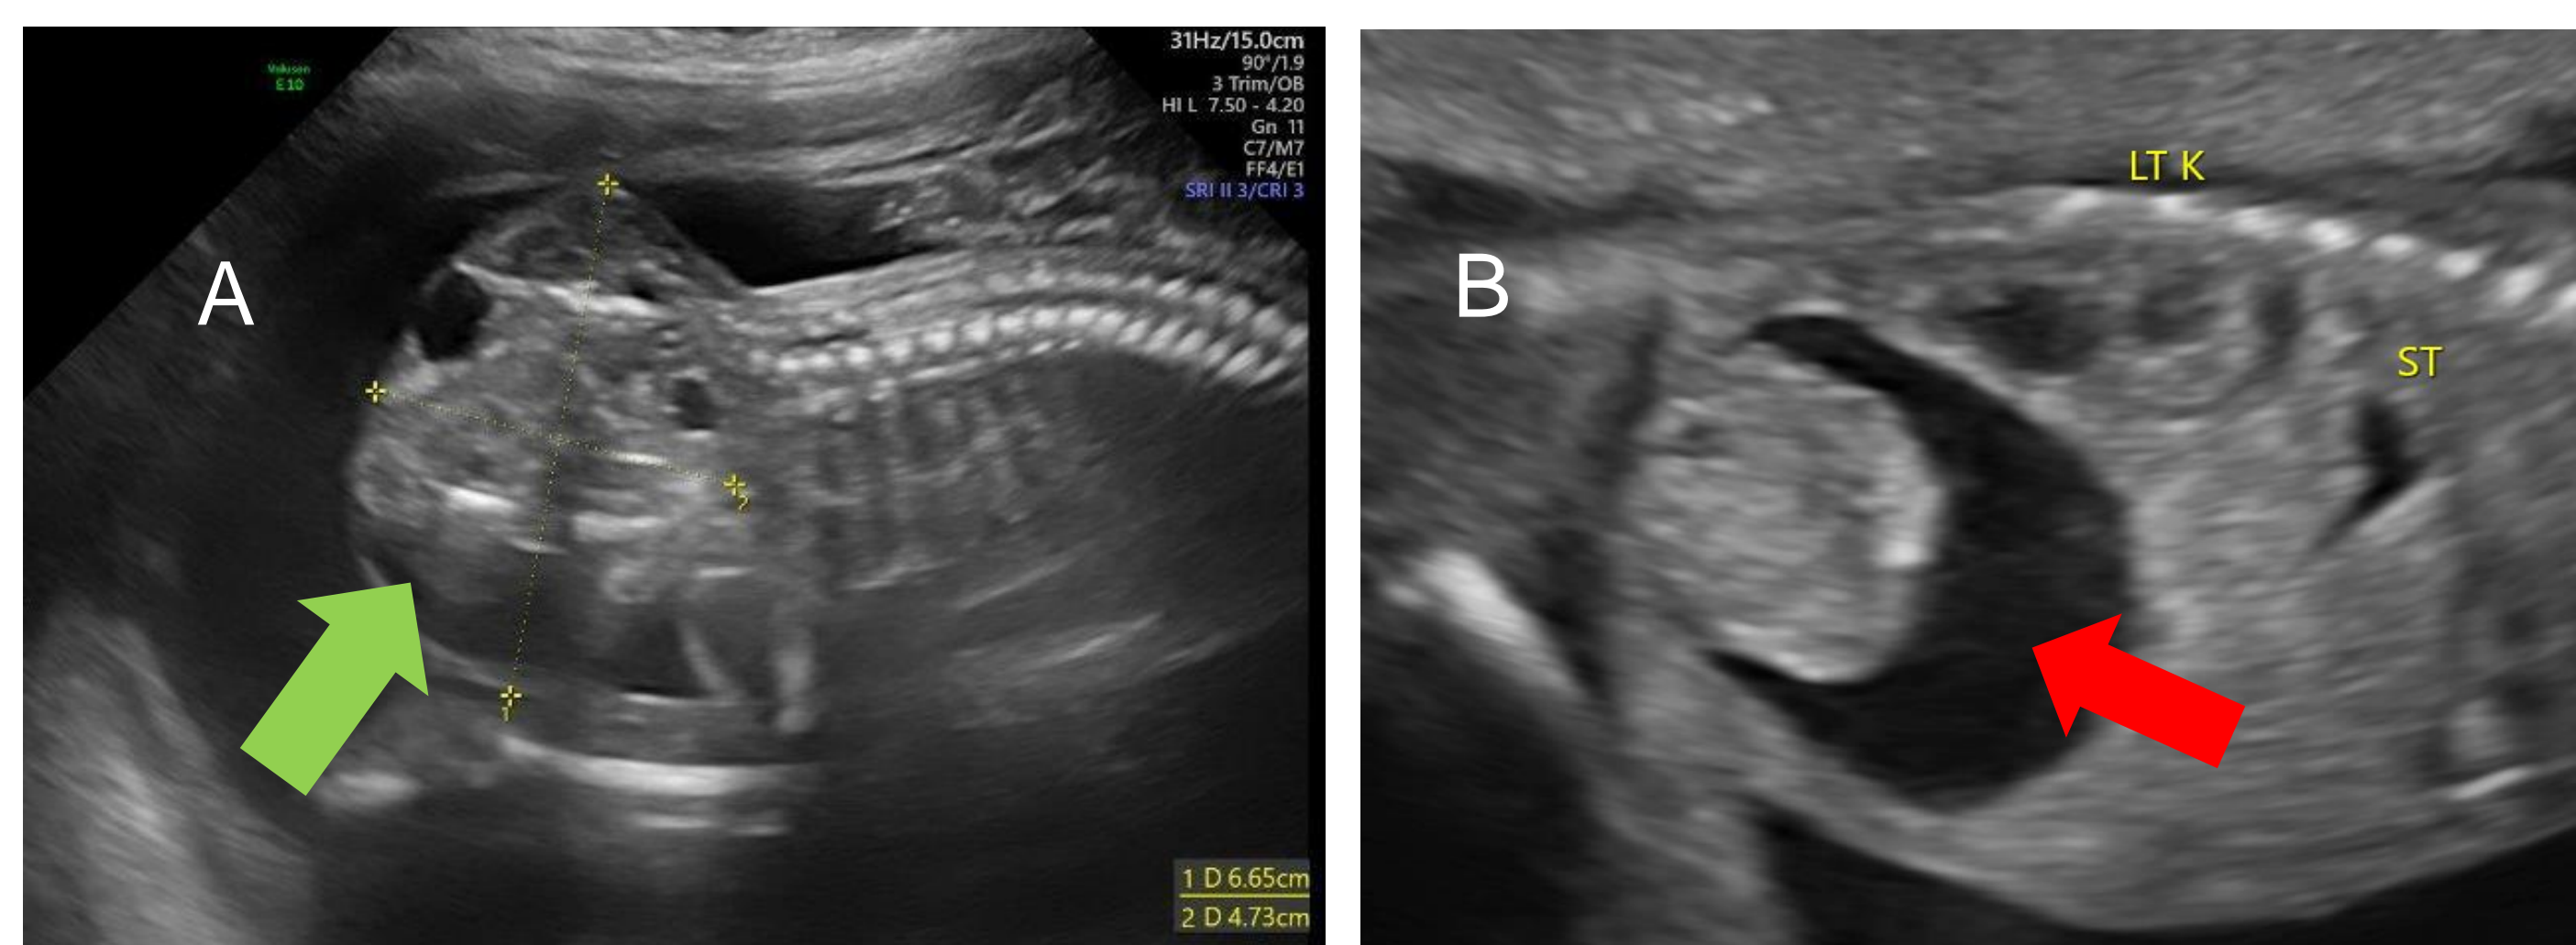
Ultrasound images: SCT (arrow) with measurements (A) and abdominal ascites (arrow) (B)
